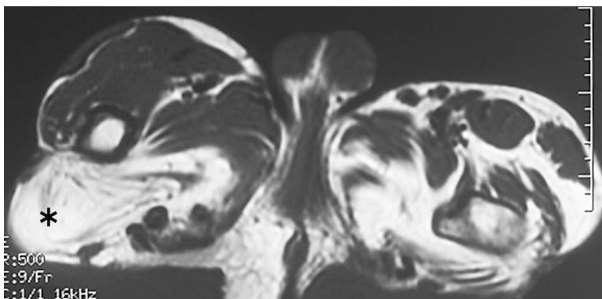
Fatty overgrowth. (19) Axial T1-weighted MR image through the level of the pelvis in a patient aged 8 years shows asymmetric adipose overgrowth along the anterior and lateral portion of the abdominal wall (*), asymmetry of the abdominal wall musculature (arrowheads), and fatty infiltration of the paraspinal muscles (arrows). (20) Axial T1-weighted MR image of the hands of a 28-year-old female patient shows marked asymmetry due to increased fatty components in the soft tissues of the right hand. The adipose overgrowth in this patient extended from the hand into the forearm. (21) Axial T1-weighted MR images of the pelvis and upper thighs (a) and the upper to middle thighs (b) in a patient aged 20 years show asymmetric muscle development in the thighs, asymmetric focal increase of fatty tissue in the right buttock (* in a), diffuse increase of fatty tissue in the left thigh, and focal accumulation of fat anterior to the left distal femur (arrow in b).
